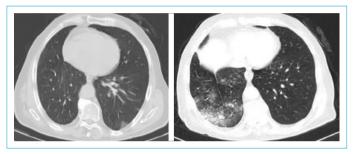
In the thorax CT of the patient who underwent right upper lobectomy, areas of viral pneumonia involvement For Review Only are seen in both lungs.
